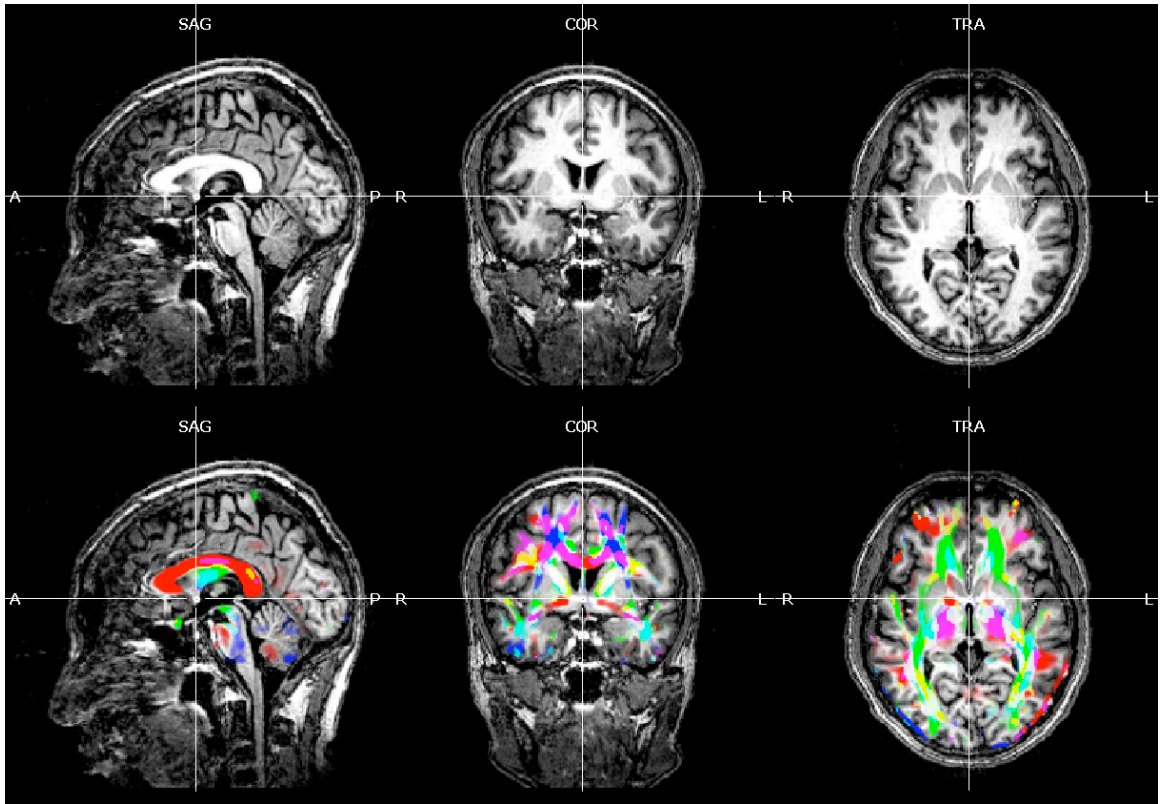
Upper panel: conventional MRI (T1-weighted image); Lower panel: DTI-based map overlaid on the same T1 image. SAG = sagittal; COR = coronal; TRA = transaxial; A = Anterior; P = posterior; R = right and L = left. Colors represent fiber orientations: Red = right-left; Green = anterior-posterior and Blue = superior-inferior.
